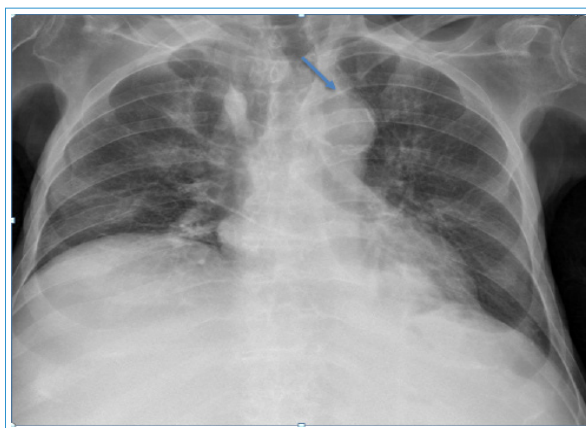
Chest X-ray demonstrating a suspicious right paratracheal fusiform opacity (arrow).
